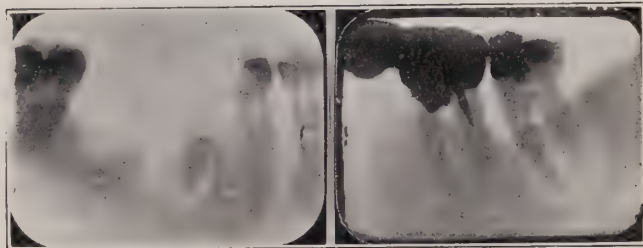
Roentgenograms showing structural changes at apices of teeth indicative of pathological lesions.
